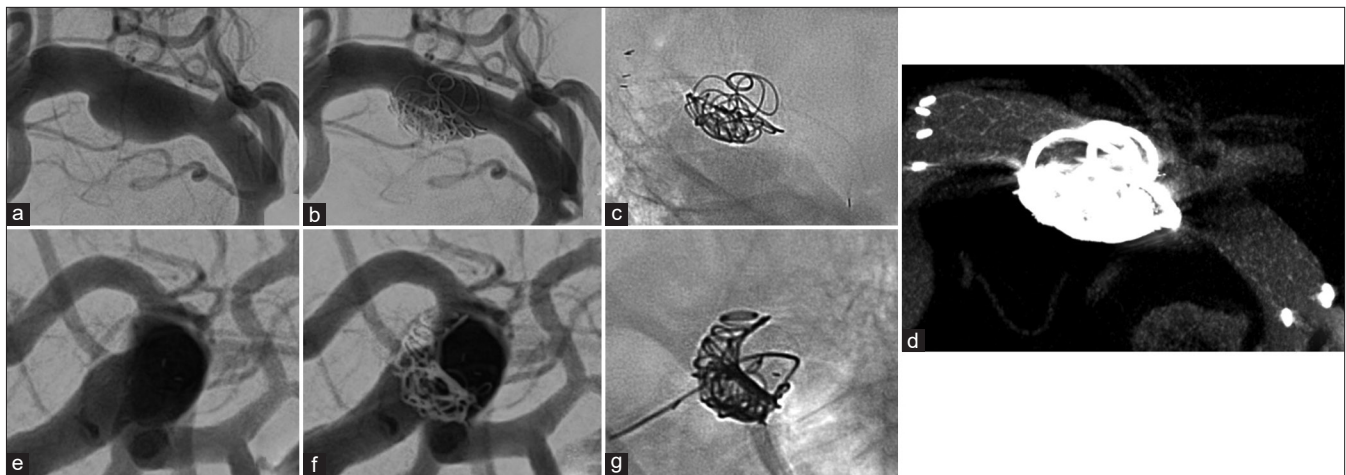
Right internal carotid artery angiograms obtained during treatment.(a-c)Anterior views, (d) anterior views of conbeam computed tomography (CT) and (e-g) lateral views. The middle columns show post stenting with coils, and the right columns show nonsubtracted views.
